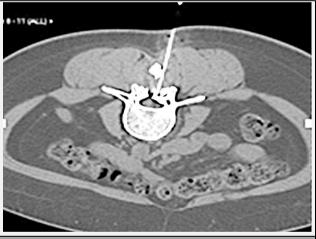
A Selected CT Image of a Patient in Prone Position Showing Needle Alignment and Adequate Position of Its Tip Reaching Right Posterolateral Epidural Space and Contrast Delineation of Space.
